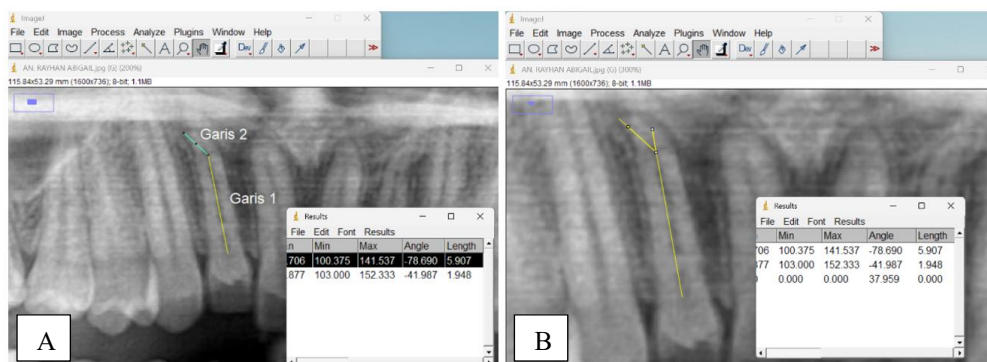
(A). Assessment of root dilaceration location on panoramic radiographs. The root length was divided into coronal, middle, and apical thirds, and the position of curvature was classified according to its anatomical location using calibrated ImageJ measurement. (B). Measurement of root dilaceration angle using the Schneider method on panoramic radiographs.
